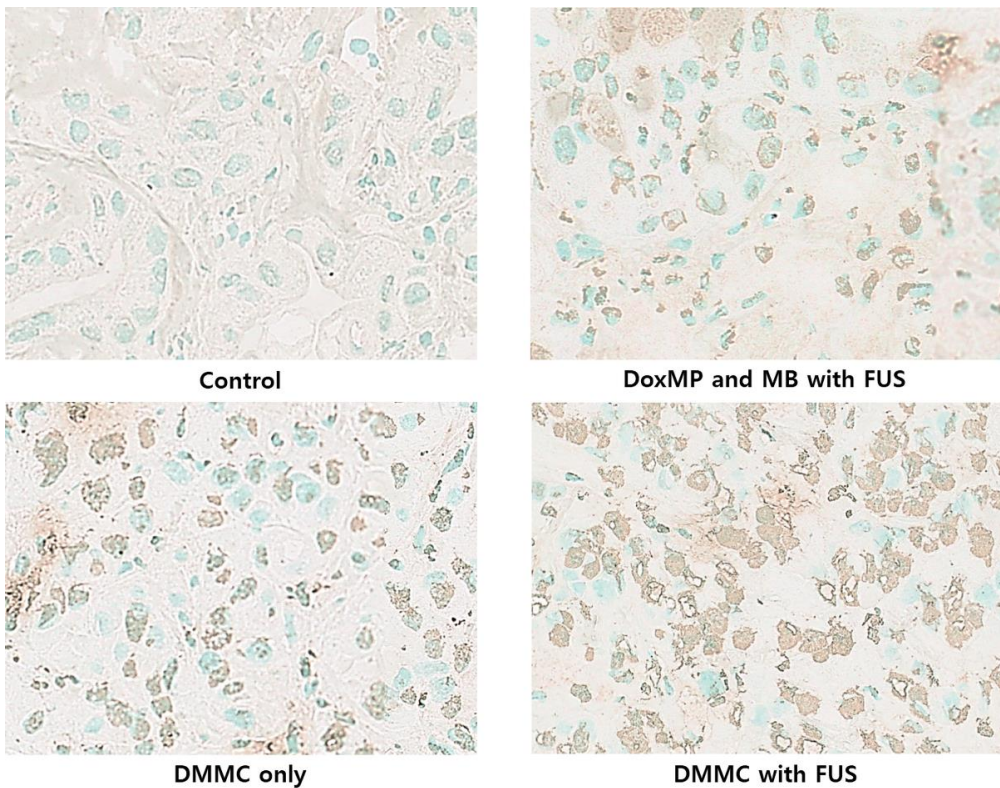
The TUNEL assay showed a significantly higher apoptotic rate in the DMMC with FUS group than in the control group. FUS, focused ultrasound; Dox, doxorubicin; MB, microbubble; DoxMP, doxorubicin-loaded microparticle; DMMC, doxorubicin-loaded microparticle-microbubble complex.
